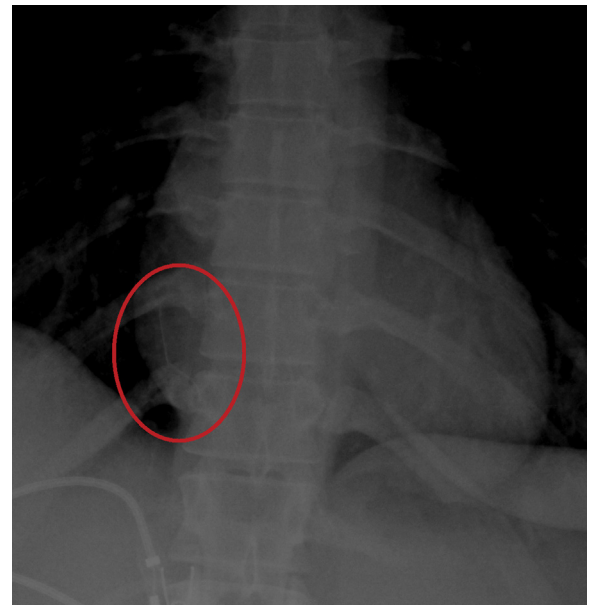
Same chest radiograph, zoomed and contrast-adjusted, demonstrating thin, radiopaque foreign body.
